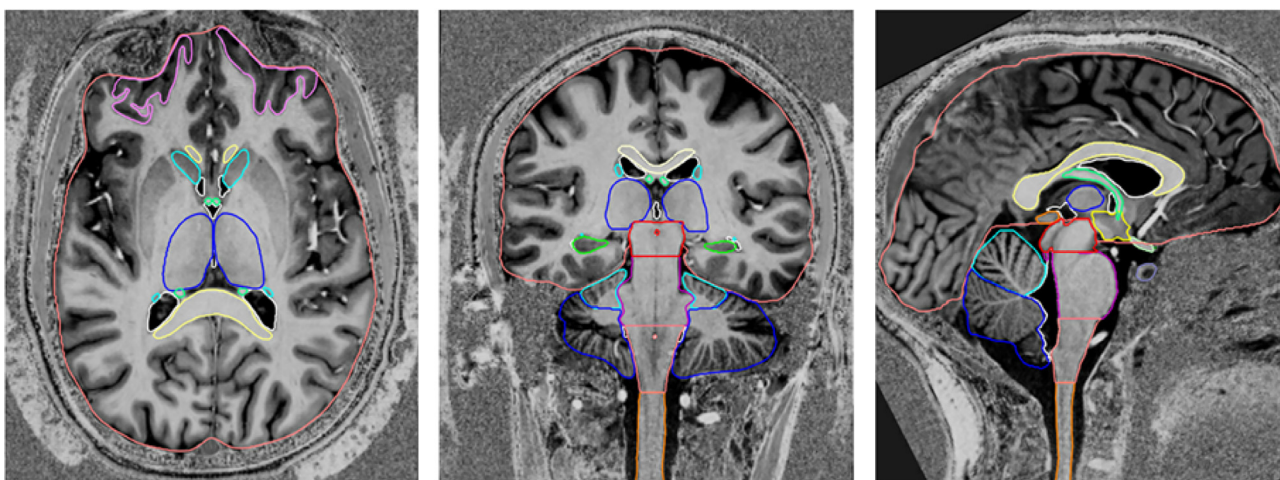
Visualisation of the organs at risk on a 7 T MRI (MP2RAGE) scan (from left to right: axial, coronal, and sagittal planes). Colour legend (in alphabetical order): Brainstem [Midbrain: red, Pons: purple, Medulla oblongata: pink]; Caudate nucleus: cyan; Cerebellum [anterior: cyan, posterior: blue]; Corpus Callosum: pale yellow; Fornix: green; Hippocampus: green; Hypothalamus: yellow; Orbitofrontal cortex: pink; Optic chiasm: light green; Pineal gland: orange; Pituitary: lavender; Spinal cord: orange; Supratentorial brain: salmon; Thalamus: blue; Ventricles: white.
